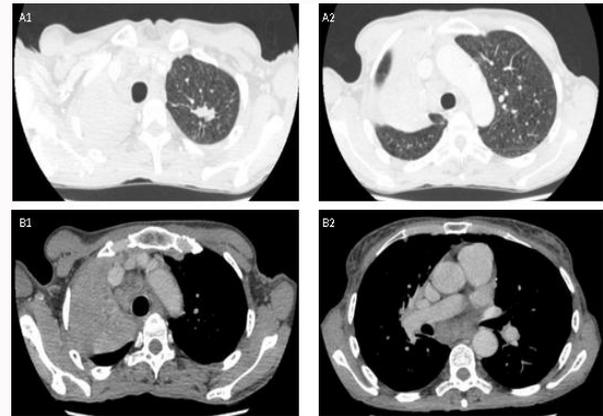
Chest CT after three months of antibacilar treatment showing: (A1-A2) complete collapse of the right upper lobe by occlusion of the respective lobar bronchus probably related to primary proliferative lesion. Changes in the left upper lobe with some nodules reduced in length and probably related to the infectious process; (B1-B2) Mediastinal window of chest CT showing adenopathies with slightly reduction compared to the previous exam.
